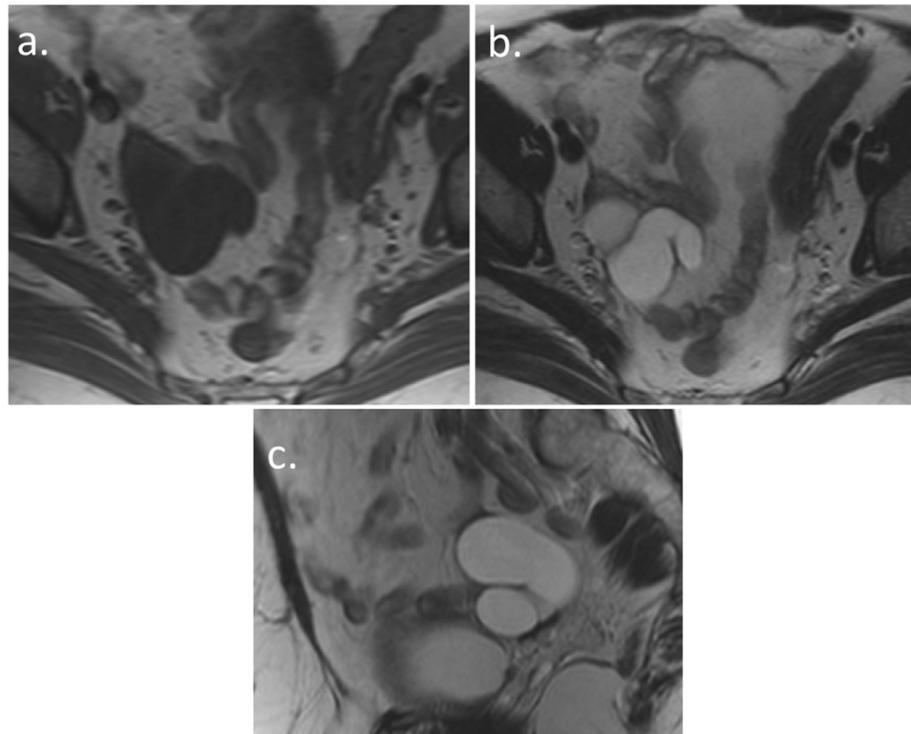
Unilateral hydrosalpinx in a 63 year-old female status-post ovarian-sparing hysterectomy. (a) T1-weighted axial (b) T2-weighted axial and (c) T2-weighted right paramedian sagittal images reveal a tubular cystic structure in the right adnexal region adjacent to the ipsilateral ovary.
